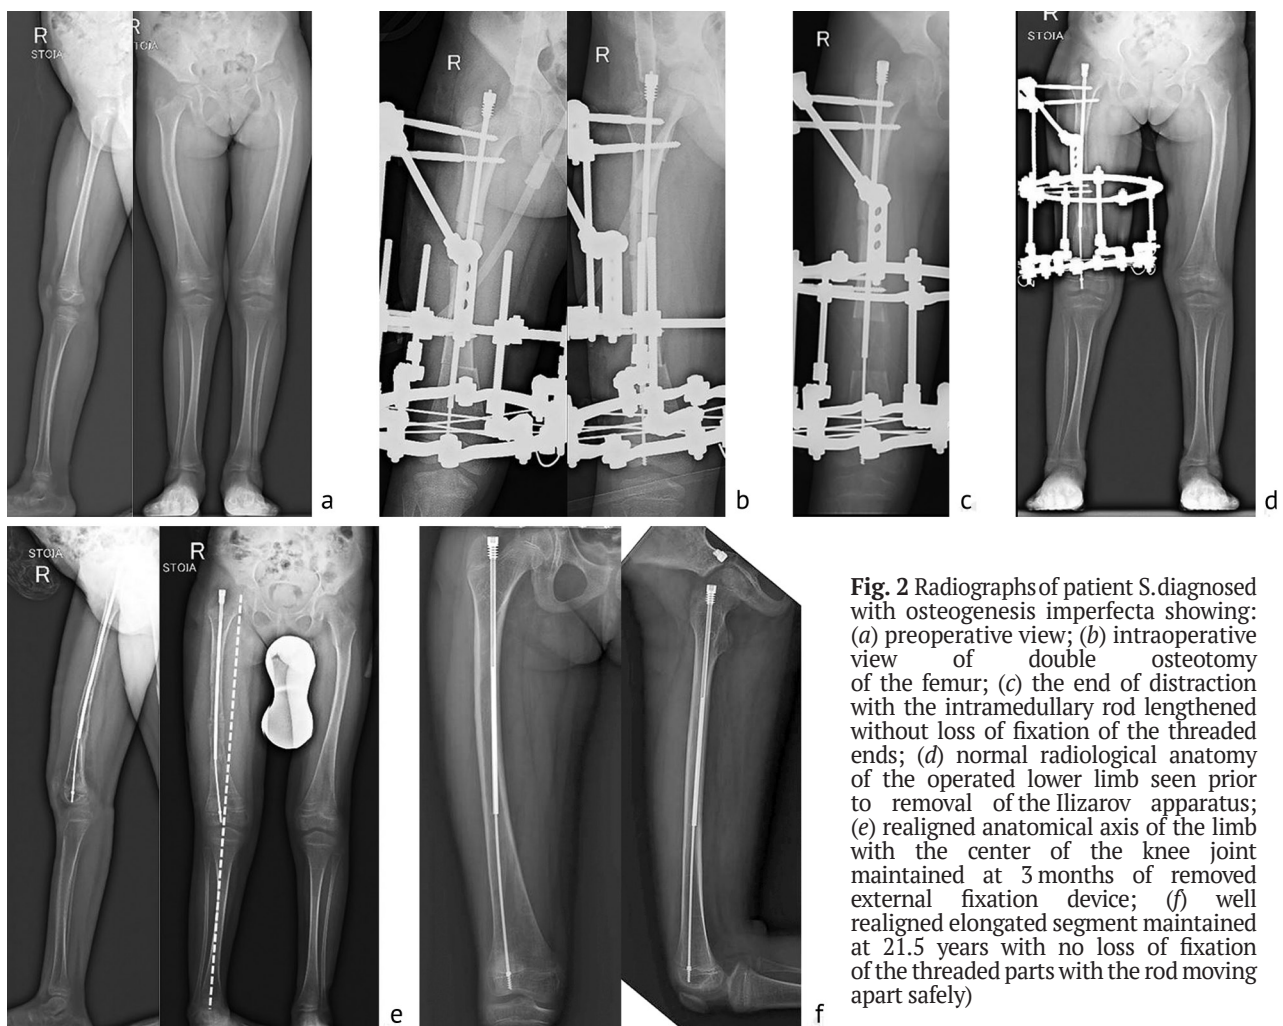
Radiographs of patient S. diagnosed with osteogenesis imperfecta showing: (a) preoperative view; (b) intraoperative view of double osteotomy of the femur; (c) the end of distraction with the intramedullary rod lengthened without loss of fixation of the threaded ends; (d) normal radiological anatomy of the operated lower limb seen prior to removal of the Ilizarov apparatus; (e) realigned anatomical axis of the limb with the center of the knee joint maintained at 3 months of removed external fixation device; (f) well realigned elongated segment maintained at 21.5 years with no loss of fixation of the threaded parts with the rod moving apart safely)
